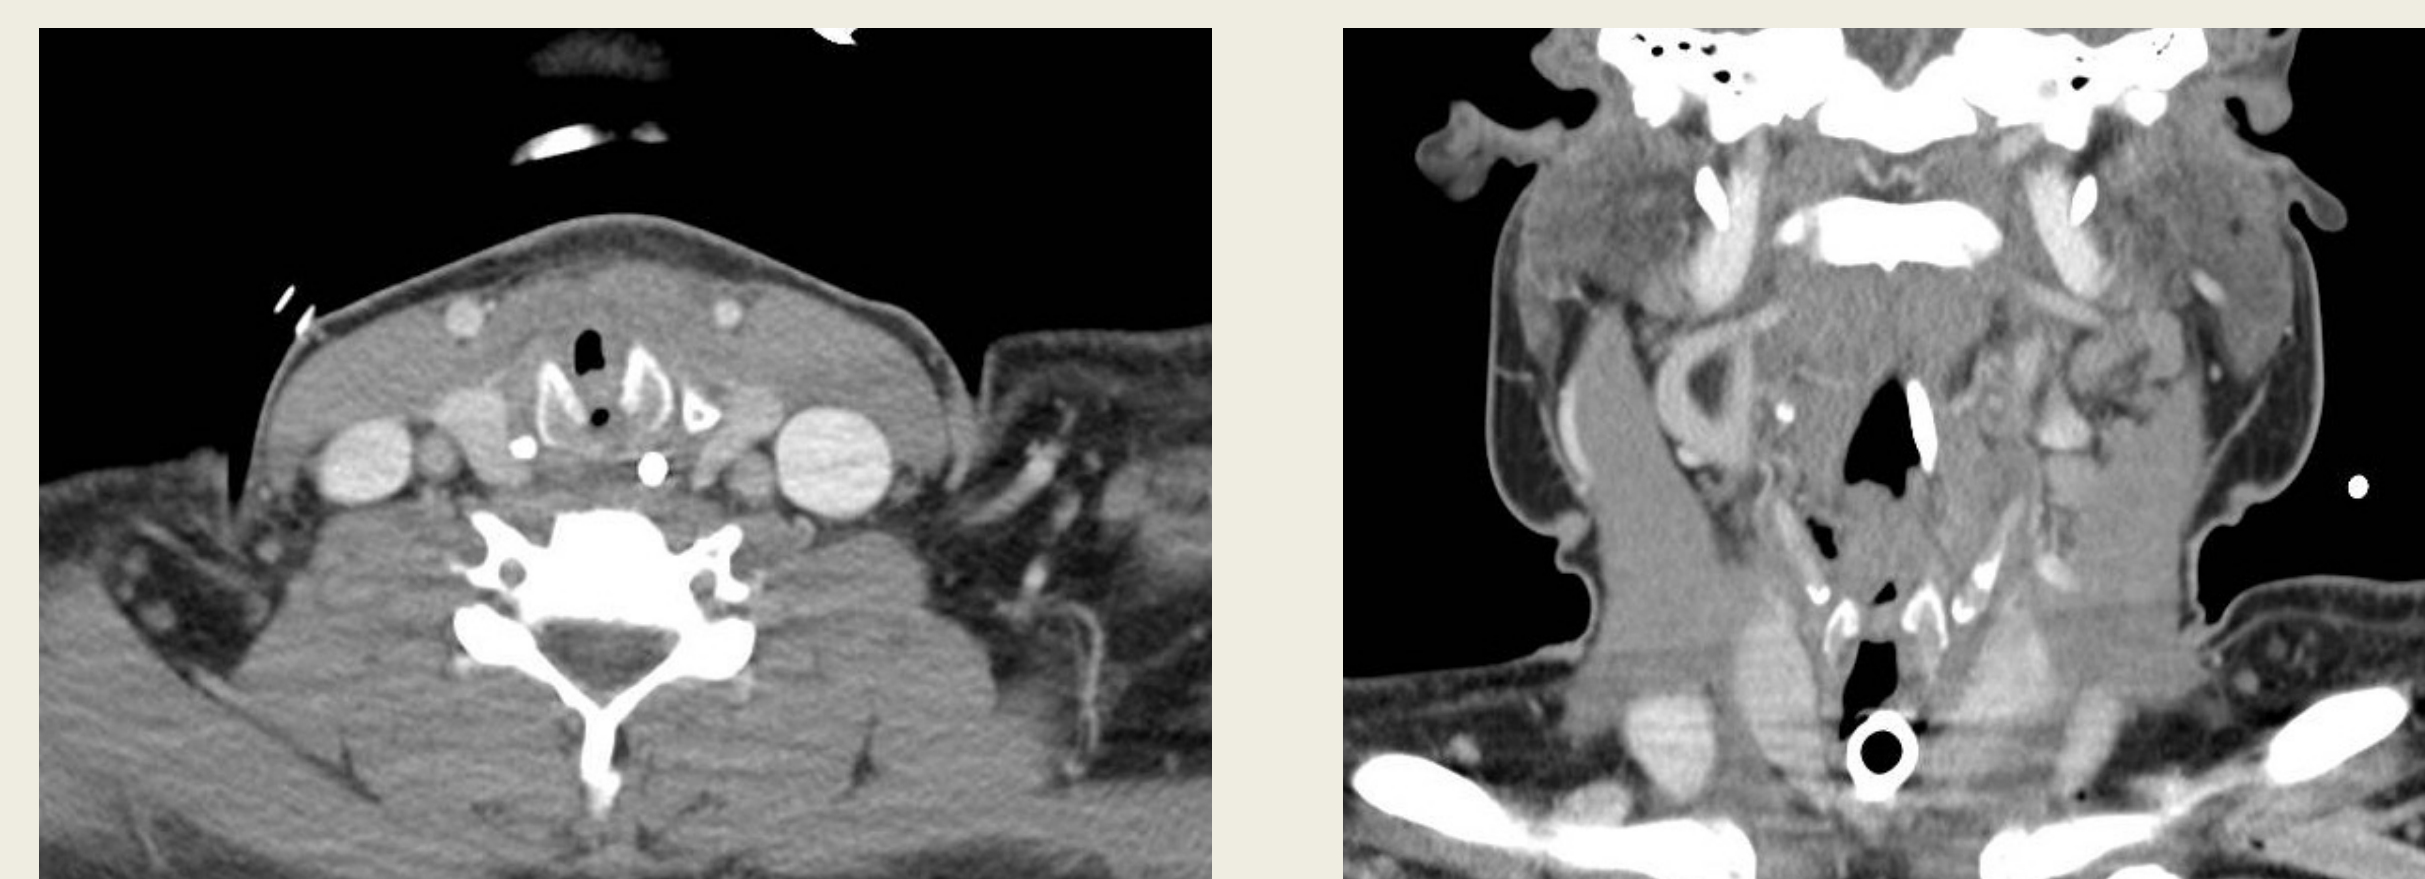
Imaging. CT neck with contrast 1 week after visualization of lesion on scope
